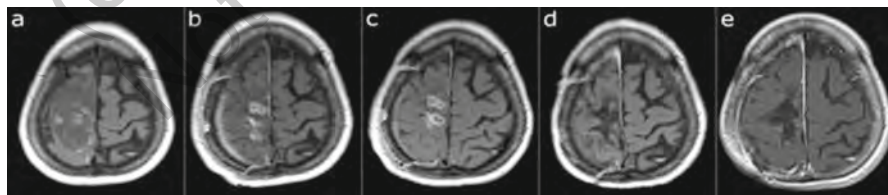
T1-weighted post-contrast MR images of a 52-year-old woman with GBM, which recurred following surgical resection and radiotherapy with concomitant daily temozolomide. (a) GBM was identified in the right central region before initial surgery. (b) Three months following surgery and after radiotherapy with concomitant daily temozolomide, two enhancing lesions suspected to be recurrent tumor were detected. (c) One month after initiation of TTFields, the caudal enhancing lesion increased in size. (d) Six months after initiation of TTFields, both enhancing lesions regressed in size. (e) Both lesions underwent complete regression 8 months after initiation of TTFields and have remained so for another 117 months. Rulseh, et al. Long-term survival of patients suffering from glioblastoma multiforme treated with tumor-treating fields. *World J Surg Oncol.* 10:220, 2012. BioMed Central
